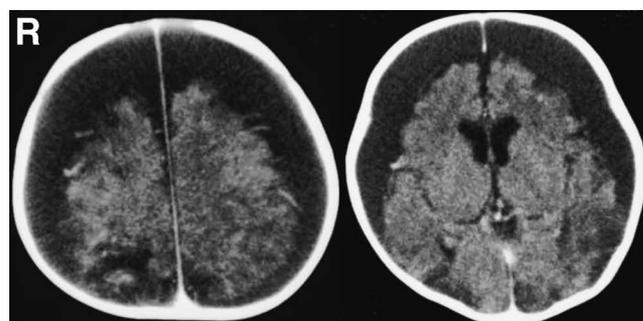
Computed tomography scans on day 14 demonstrating residual subdural hematomas with marked diffuse brain atrophy in the bilateral cerebral hemispheres, but no evidence of hemorrhagic change in the cerebral hemispheres.
